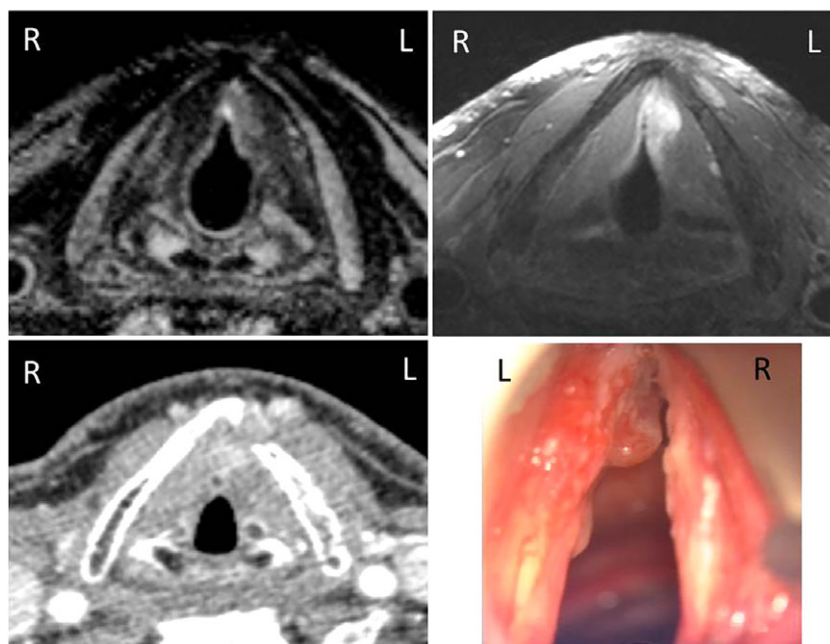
Axial images at the mid glottic level showing a lesion on the anterior half of the left true vocal cord with extension to the anterior commissure (arrows). On CT the lesion is isointense to the vocal cord and therefore difficult to see. 3 T MRI (a), 7 T MRI (b), contrast enhanced CT (c) and clinical photo during suspension laryngoscopy (d) of the same study patient. 3 T = 3 Tesla; 7 T = 7 Tesla; CT = computed tomography; MRI = magnetic resonance imaging.
